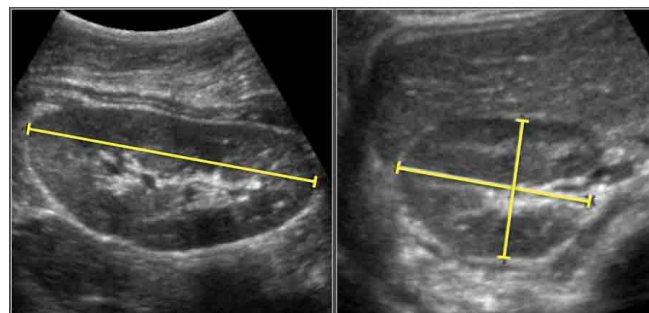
Sonographic normal renal measurements
